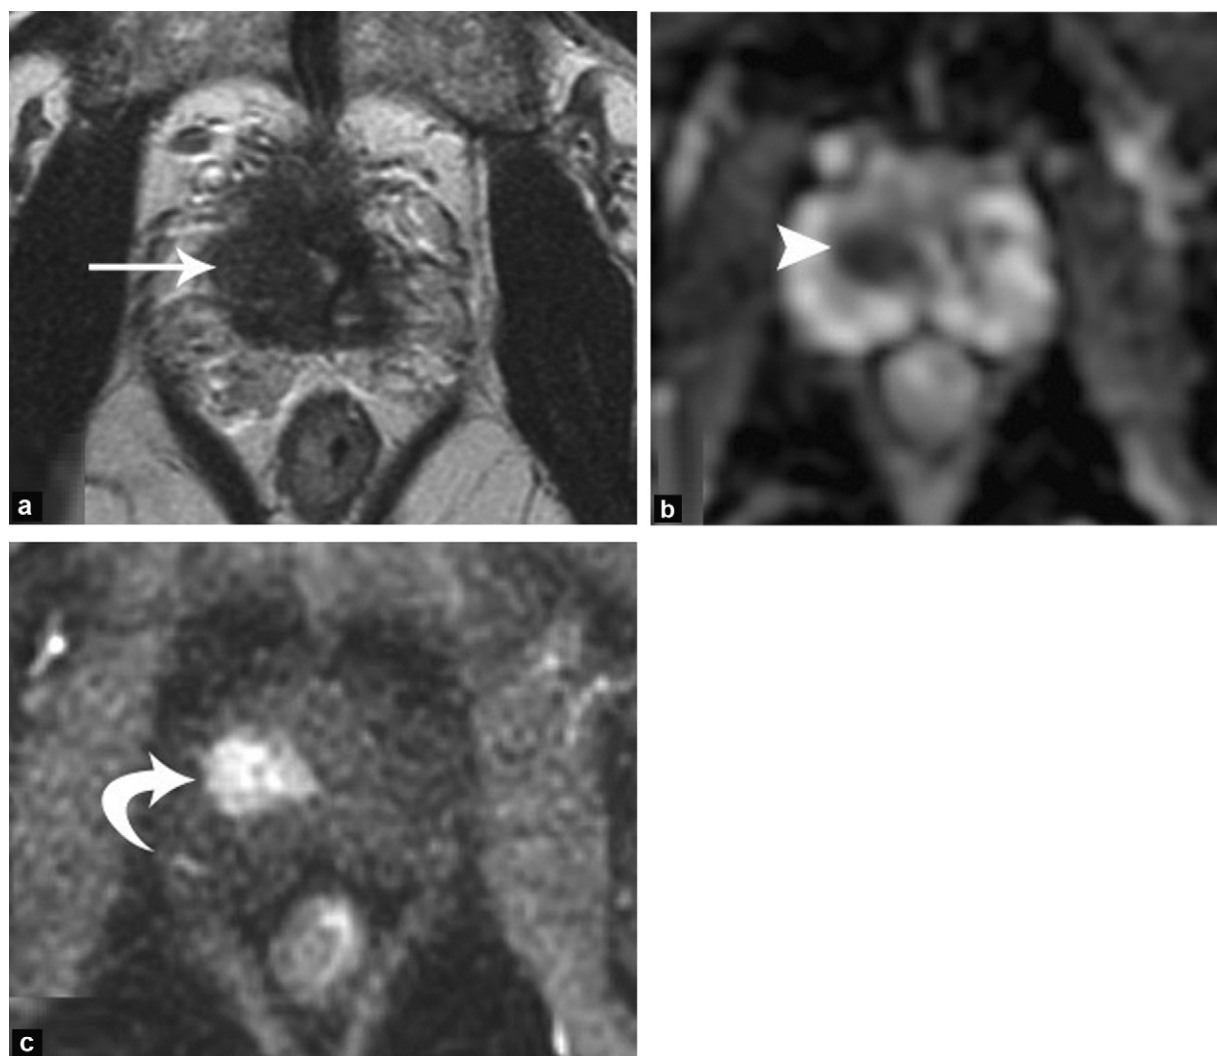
A 78-year-old patient treated with focused ultrasound 6 years previously for a Gleason 7 prostatic adenocarcinoma with a PSA of 20 ng/mL. After a PSA nadir at 0 ng/mL, the level rose again progressively to 3 ng/mL: a: T2-weighted axial slice showing a right basal nodule as a discrete hypointense (arrow); b: axial section, ADC map: the nodule is much more visible (arrowhead); c: the dynamic axial slice after contrast agent injection also shows this nodule better (curved arrow). Targeted biopsies showed a Gleason 7 adenocarcinoma of the mid part and the right base.
